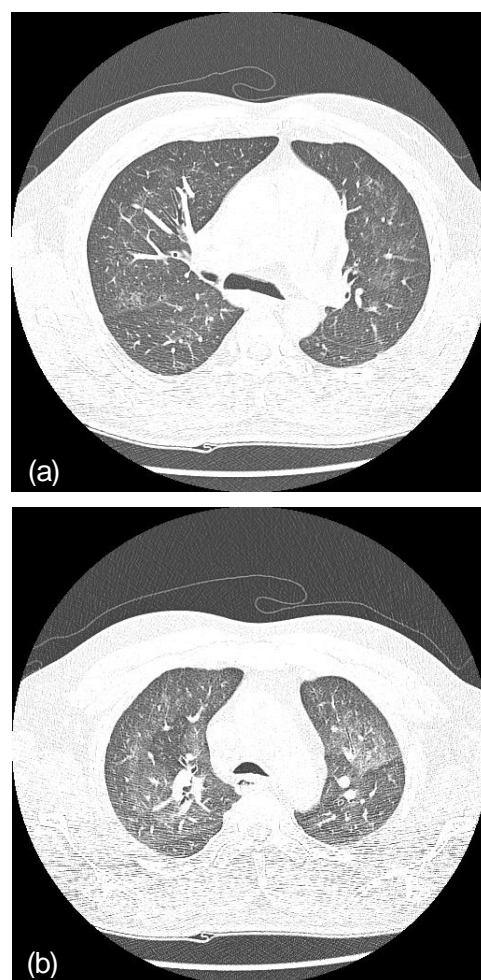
HRCT scan (a) shows multifocal, ill-defined, ground glass opacities, and expiratory CT scan (b) shows associated air trapping (low density areas) in hypersensitivity pneumonitis.
